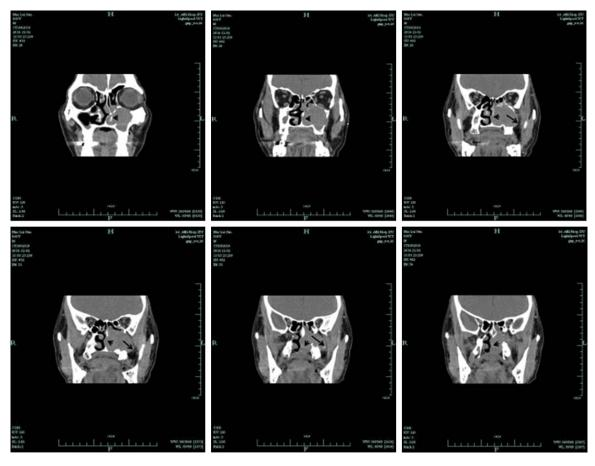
Computed tomography, axial view, demonstrating a large isodense softtissue mass occupying the entire left maxillary sinus and causing destruction of bone (arrow).
